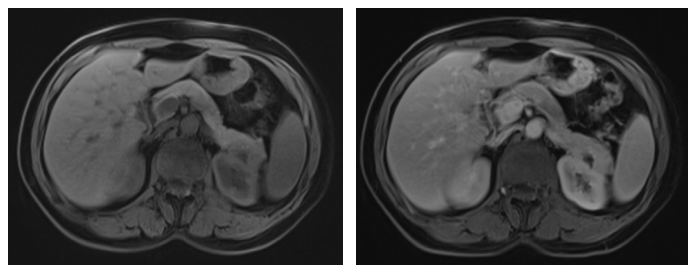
T1 Weighted, fat saturated T1 weighted (Contrast-enhanced abdominal magnetic resonance images of the patient)
